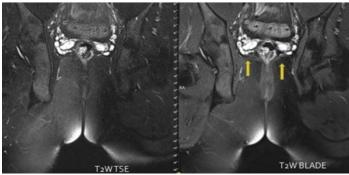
Coronal plane of the T2-weighted (T2-W) turbo spin echo sequence and T2W BLADE sequence images of the same patient. Levator plates (thick yellow arrows), which are an essential landmark in fistula classification, are clearly distinguishable in the T2-W BLADE sequence image with a high-contrast resolution.
